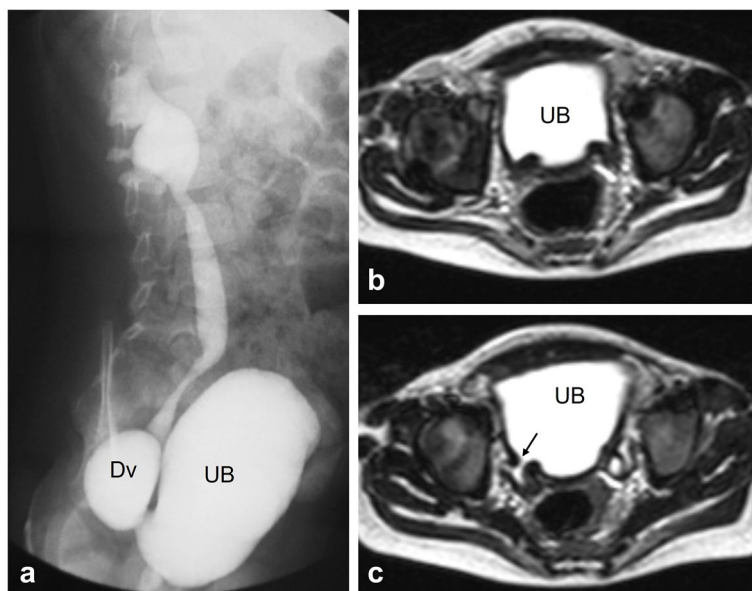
Second case with accessory communication between the lower urinary tract and the anus. a Cystogram demonstrating vesico-ureteric reflux and posterior bladder diverticulum (hutch diverticulum). b, c Axial pelvic MRI (T2WI) demonstrating the opening of diverticulum (arrow). UB, urinary bladder; Dv, bladder diverticulum
